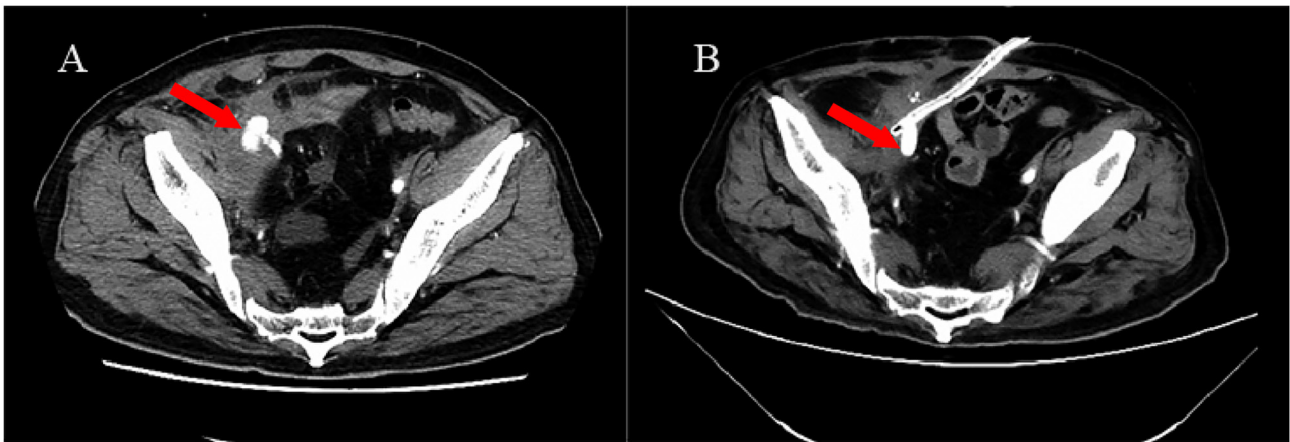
(A) Abdominal enhanced CT scan showed diffuse extravasation of the contrast medium from the right external iliac artery before surgery, as indicated by the red arrow. (B) Postoperative CT scan showed no medium effusion after surgery, with placement of a vascular stent and abdominal drainage tube.
